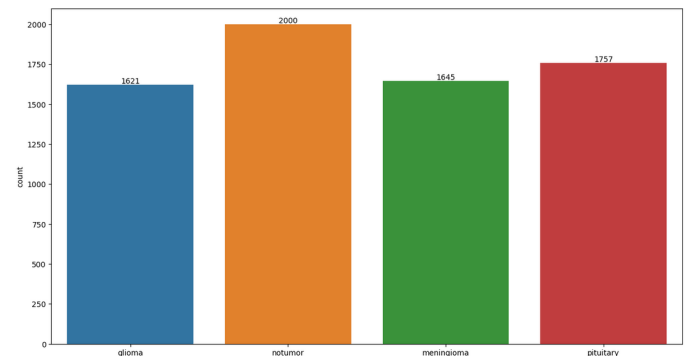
Class-wise distribution of brain MRI images in the dataset, showing the number of samples for glioma, no tumor, meningioma, and pituitary tumor classes.
